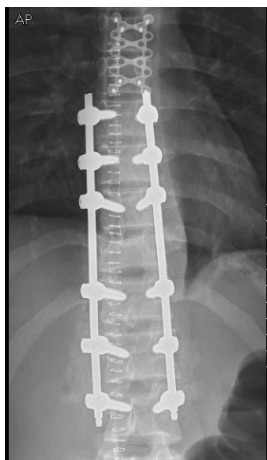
Post-operative x-ray showing AP view of the pedicle screws as well as sternal plating
